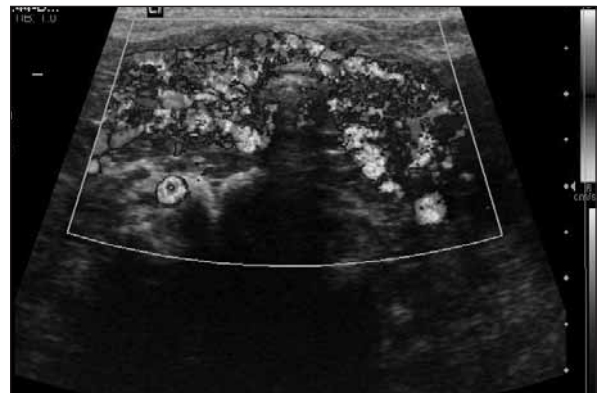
After birth, color Doppler examination showed a diffusely enlarged thyroid gland.
